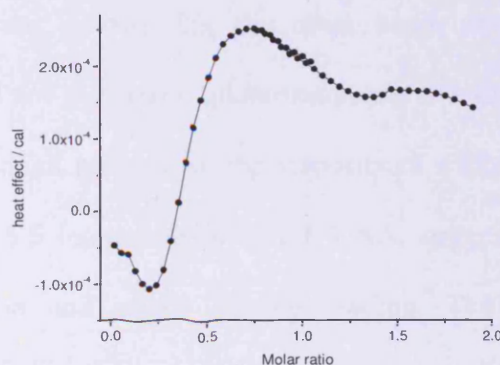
Combined heat effects for a series of two ITC experiments involving dicationic quaterthiophene 5.5 and CT-DNA in 25 mM MOPS, 50 mM NaCl and 1 mM EDTA, pH 7.0 at 25 °C.
